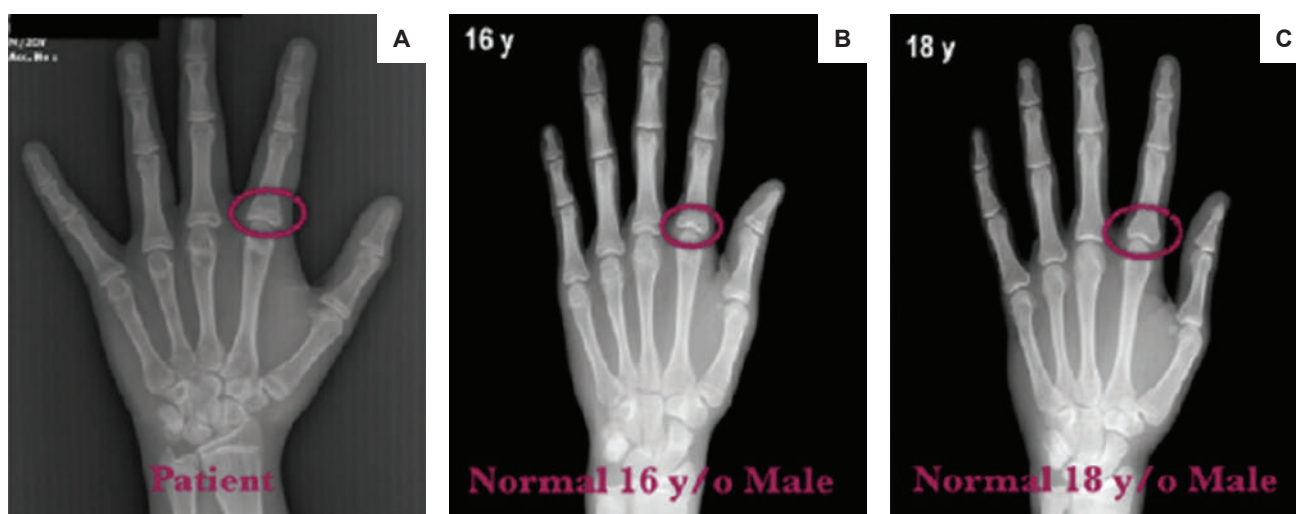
X-ray of left hand comparing (A) patient's bone age, (B) normal 16-year-old male and (C) normal 18-year-old male.
